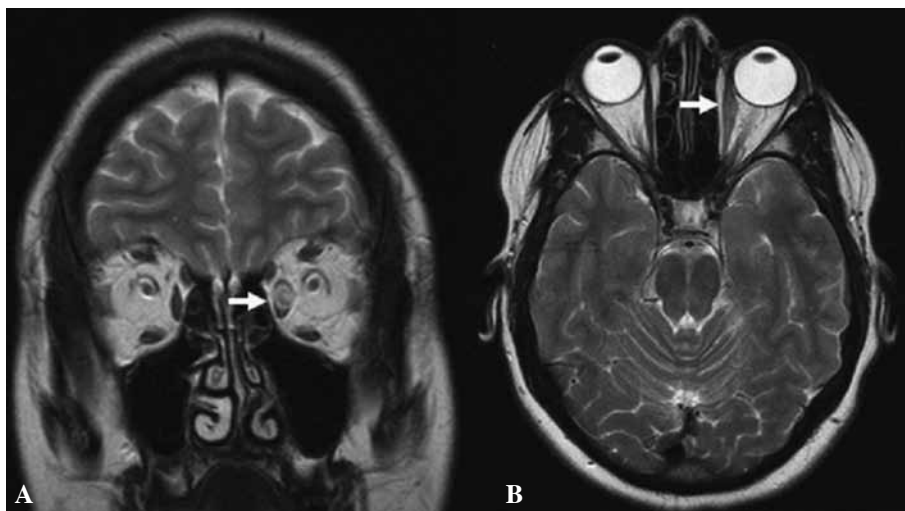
MRI without contrast showing T2-weighted thickening of left medial rectus (arrows). (A) Coronal image. (B) Axial image.
